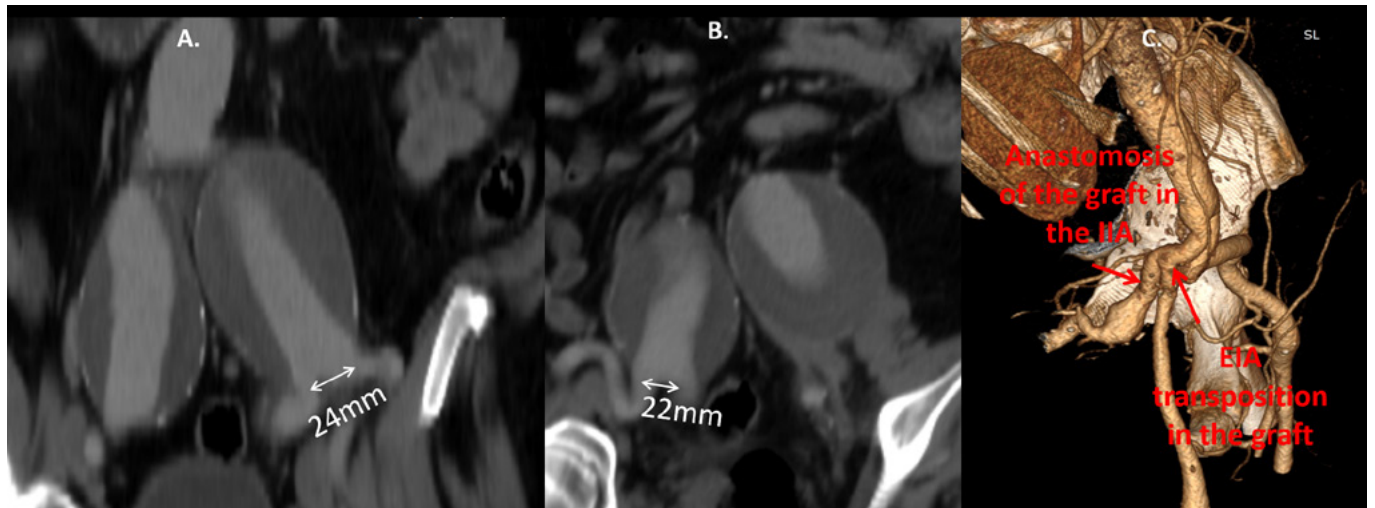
Coronal views indicating wide left (2A) and right (2B) iliac bifurcations and 3-Dimensional reconstruction of the post-operative CT angiography (2C), of 2nd patient.
